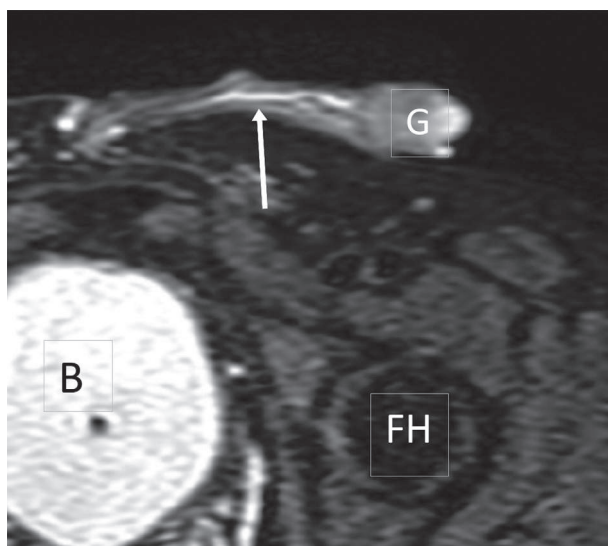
T2 w TSE axial MRI of the pelvis of a forty nine year-old man with history of prior intense biking activity with chronic pain at the left gluteal region extended to the scrotal area and lower left leg: the left piriformis muscle is almost totally replaced by fat (arrow) with entrapment of sciatic and pudendal nerve at the exit of the lesser sciatic foramen TSE: Turbo spin echo, MRI: Magnetic resonance imaging, FH: Femoral head, Gl: Gluteus max muscle, B: Bladder, P: Piriformis muscle, Sc: Sciatic nerve
